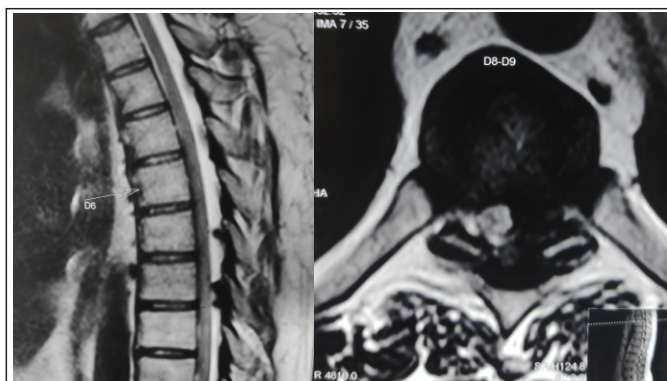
(a) A 4-year-old MRI sagittal T2-image showing compression at D8-9 level and (b) A 4-year-old MRI axial T2-image showing posterocentral and left posterolateral mass arising from ligamentum flavum.
